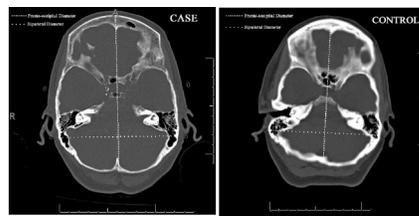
The axial CT scans of a patient with Moyamoya disease and age/gender/race matched control demonstrating measurement of fronto-occipital and bi-parietal diameters.
